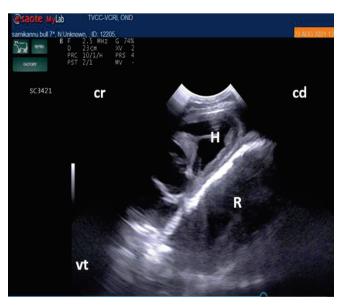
Ultrasonography heart at 4th ICS space showing compressed cardiac chambers with reticular wall (cr-Cranial, cd – caudal, H- Heart, R- Reticulum and vt-ventral)
